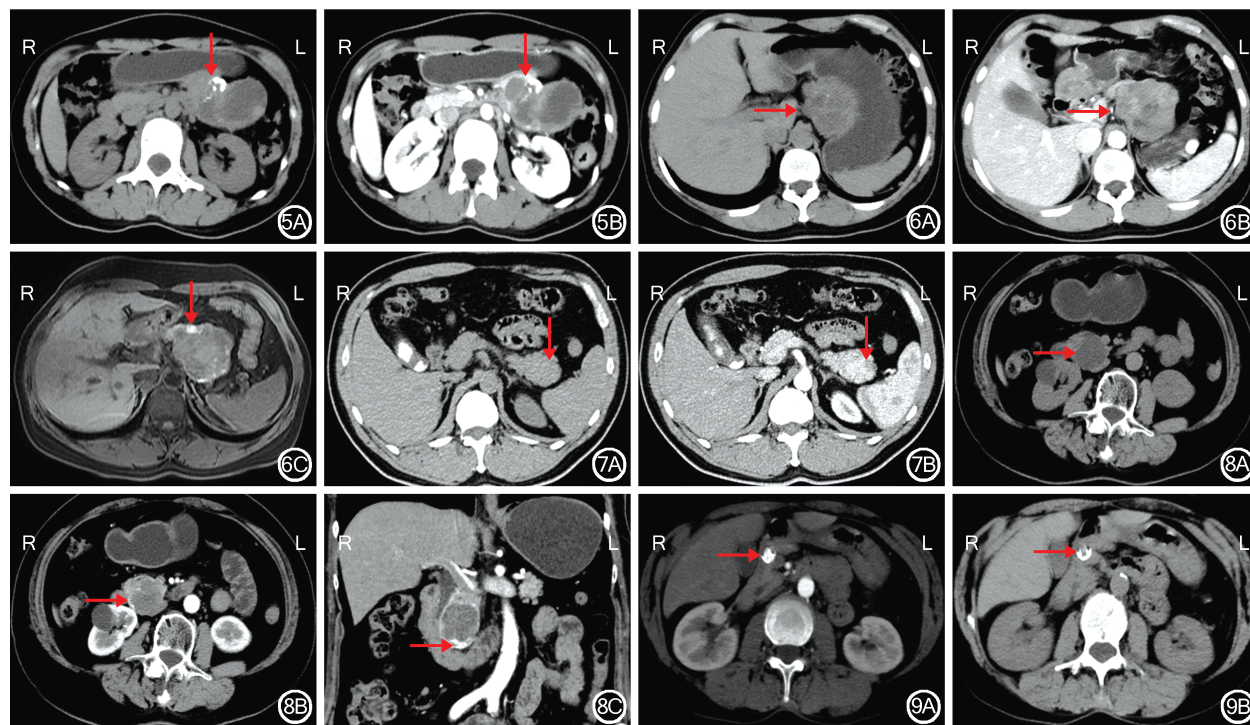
实性假乳头状瘤病人的 CT 检查结果 5A:CT 检查平扫结果显示胰腺尾部混杂密度影,向外生长,囊性为主,边缘可见斑片状钙化影(↓);5B:CT 检查增强扫描结果显示门静脉期肿瘤囊性坏死,实性部分强化明显(↓),液性部分未见强化 5C:CT 检查平扫结果显示胰腺尾部分叶状肿瘤,密度不均,内见点状钙化(→);5D:CT 检查增强扫描结果显示门静脉期肿瘤不均匀强化,中央囊性坏死(→);5E:MRI 检查示 T1 加权成像肿瘤边缘出血呈高信号影(↓) 5F:MRI 检查示 T1 加权成像肿瘤边缘出血呈高信号影(↓) 5G:CT 检查平扫结果显示胰腺头部囊性肿瘤(→),边界清楚;5H:CT 检查增强扫描显示动脉期肿瘤边缘强化(→);5I:CT 检查冠状位重建检查结果显示肿瘤边缘见粗大杂乱的血管影(→) 5J:CT 检查平扫结果显示胰腺颈部混杂密度结节,边缘钙化(→);5K:CT 检查增强扫描结果显示结节强化明显,边缘可见低密度未强化血栓影(→)
